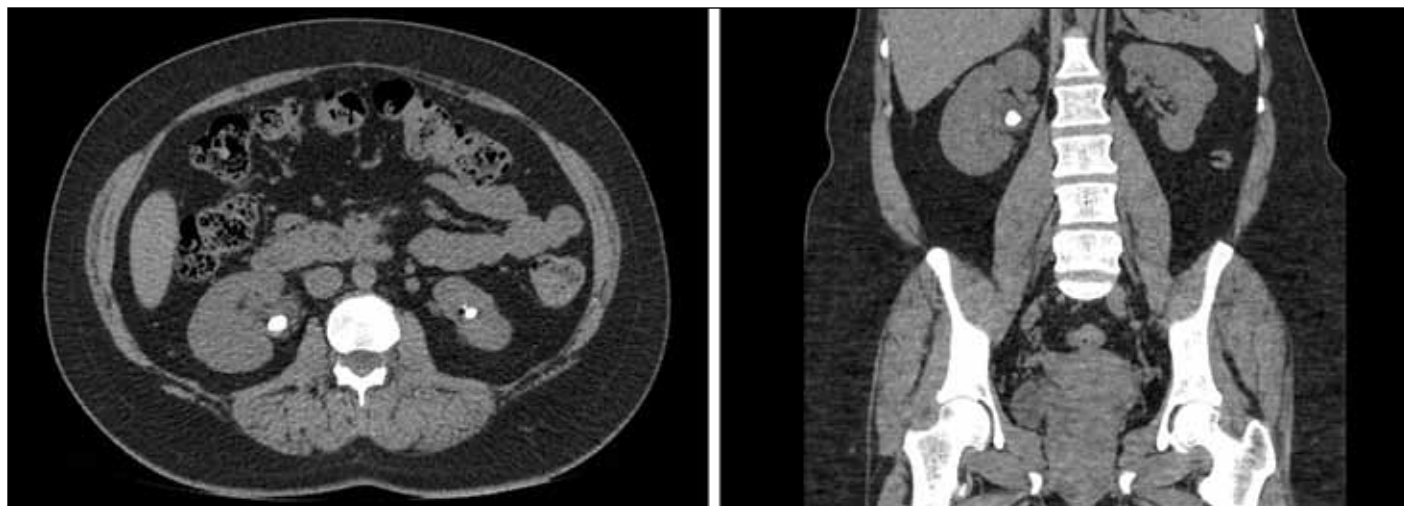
Preoperative computed tomography images showing right renal pelvis calculus in transverse (*left*) and coronal (*right*) views.
